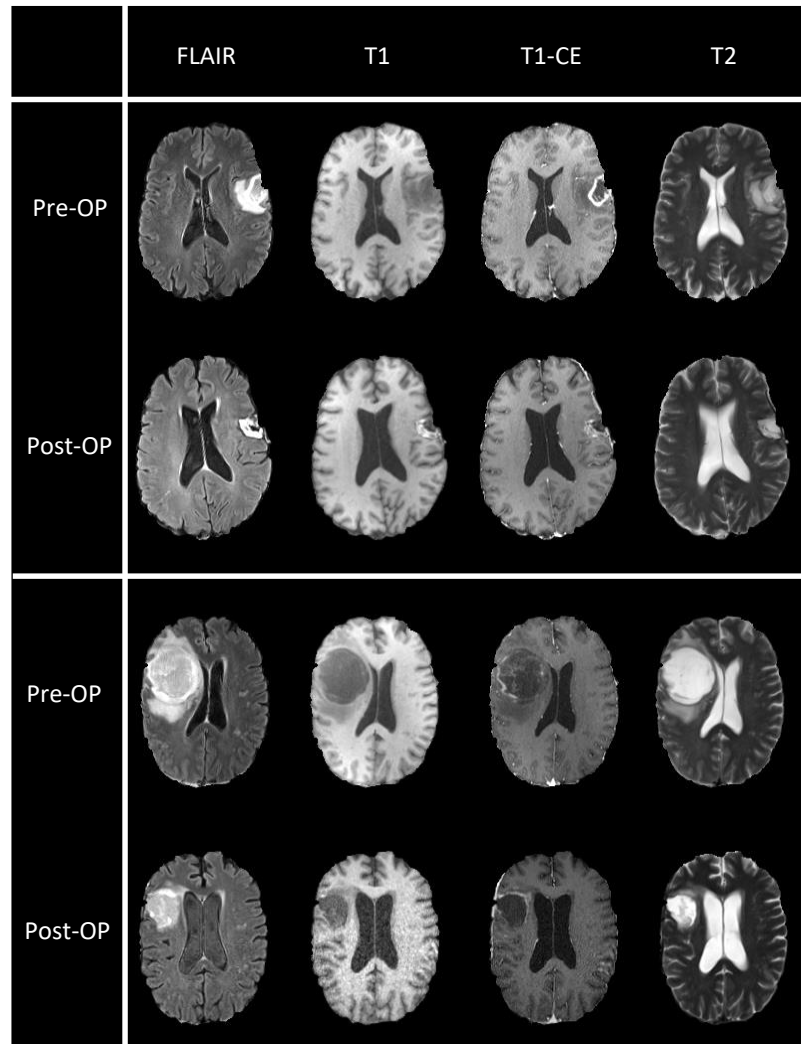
Pre-operative (Pre-OP) and post-operative (Post-OP) MR scans of two glioma patients, including four sequences each: native T1-weighted (T1), contrast-enhanced T1 (T1-CE), T2-weighted (T2), and T2 Fluid Attenuated Inversion Recovery (FLAIR). Missing correspondences due to tissue deformation and intensity shifts, induced by the tumor, complicate image registration.
